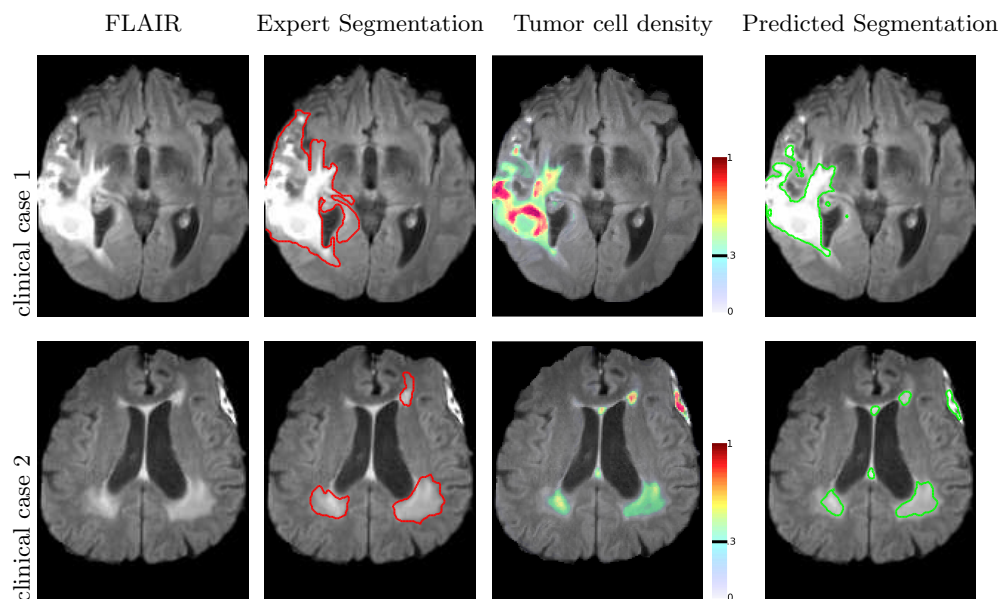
Segmentation and tumor cell distribution. From left to right: pre-processed Flair MR image, FLAIR MR image overlaid with the segmentation of an expert, the normalized tumor cell density, and the predicted tumor segmentation (threshold at 0.3).
